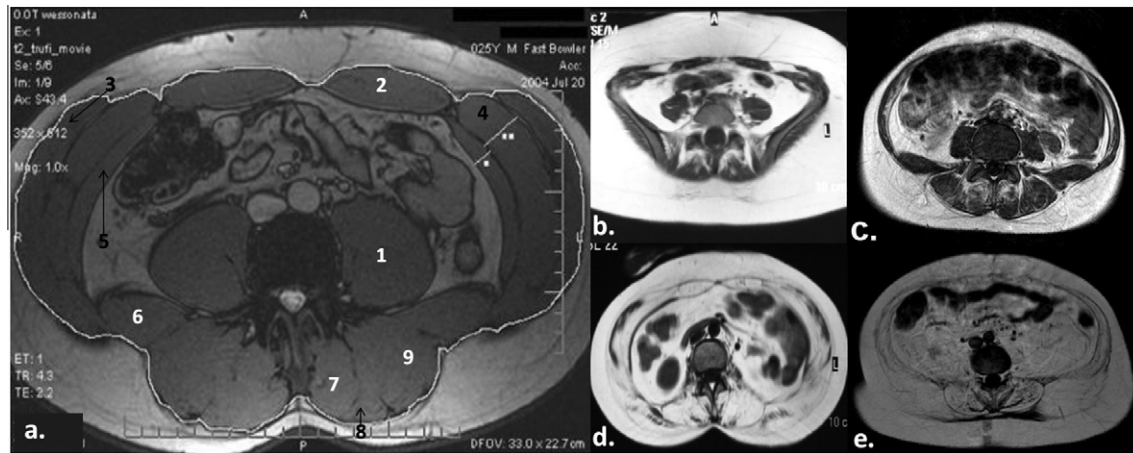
MRI involvement of trunk muscles. Normal abdominal and paravertebral muscles slice (a): *Psoas* muscle (1), *Rectus Abdominis* (2), *Obliquus Externus Abdominis* (3), *Obliquus Internus Abdominis* (4), *Transversus Abdominis* (5), *Quadratus Lumborum* (6), *Multifidus* muscle (7), *Longissimus* muscle (8), *Iliocostal Lumborum* (9). Asymptomatic patient number 1 (b). Mild clinical stage patient number 10 (c). Moderate clinical stage patient number 13 (d). Severe clinical stage patient number 27 (e).
